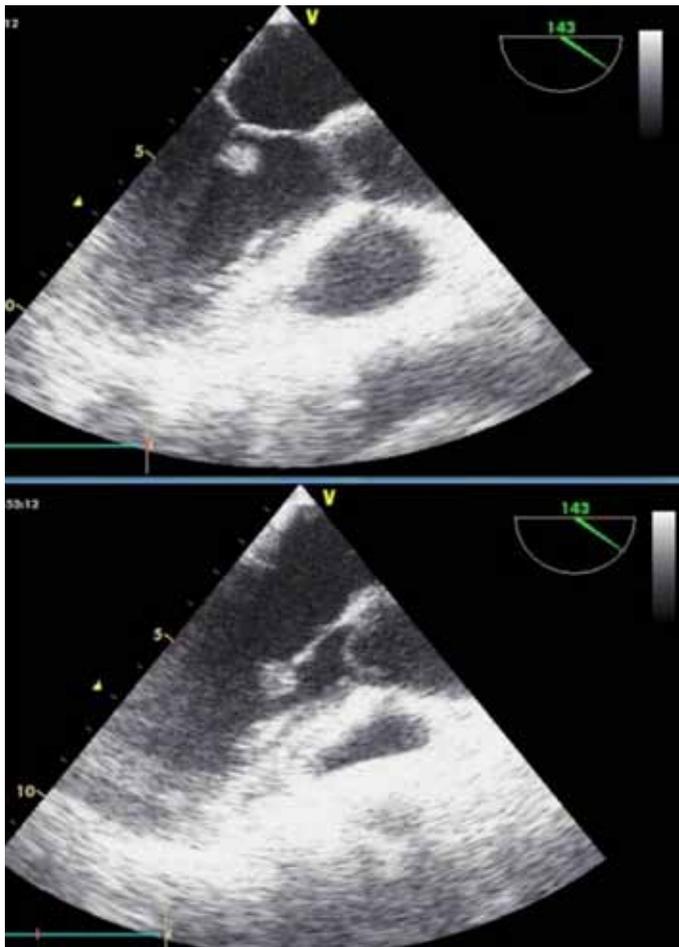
Transesophageal echocardiography shows an isolated tumor of the mitral valve chordae
